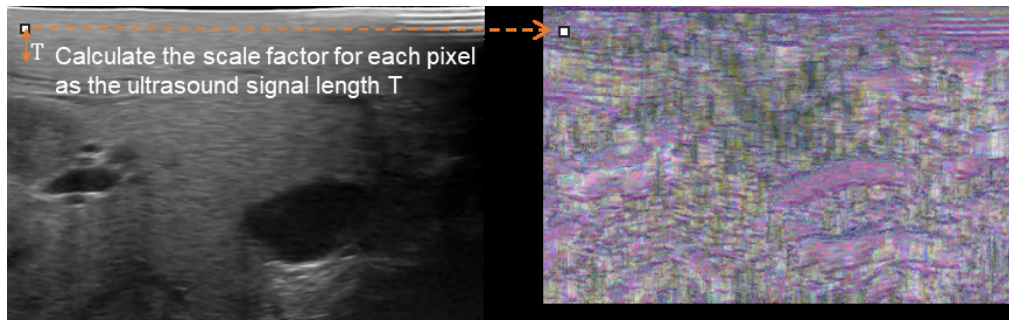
Conversion of an ultrasound image to a scaling factor map with a crop window size of $T=40$. The scaling factor map depicts the scaling factors for the cos, sin, and envelope components as a three-color image.
